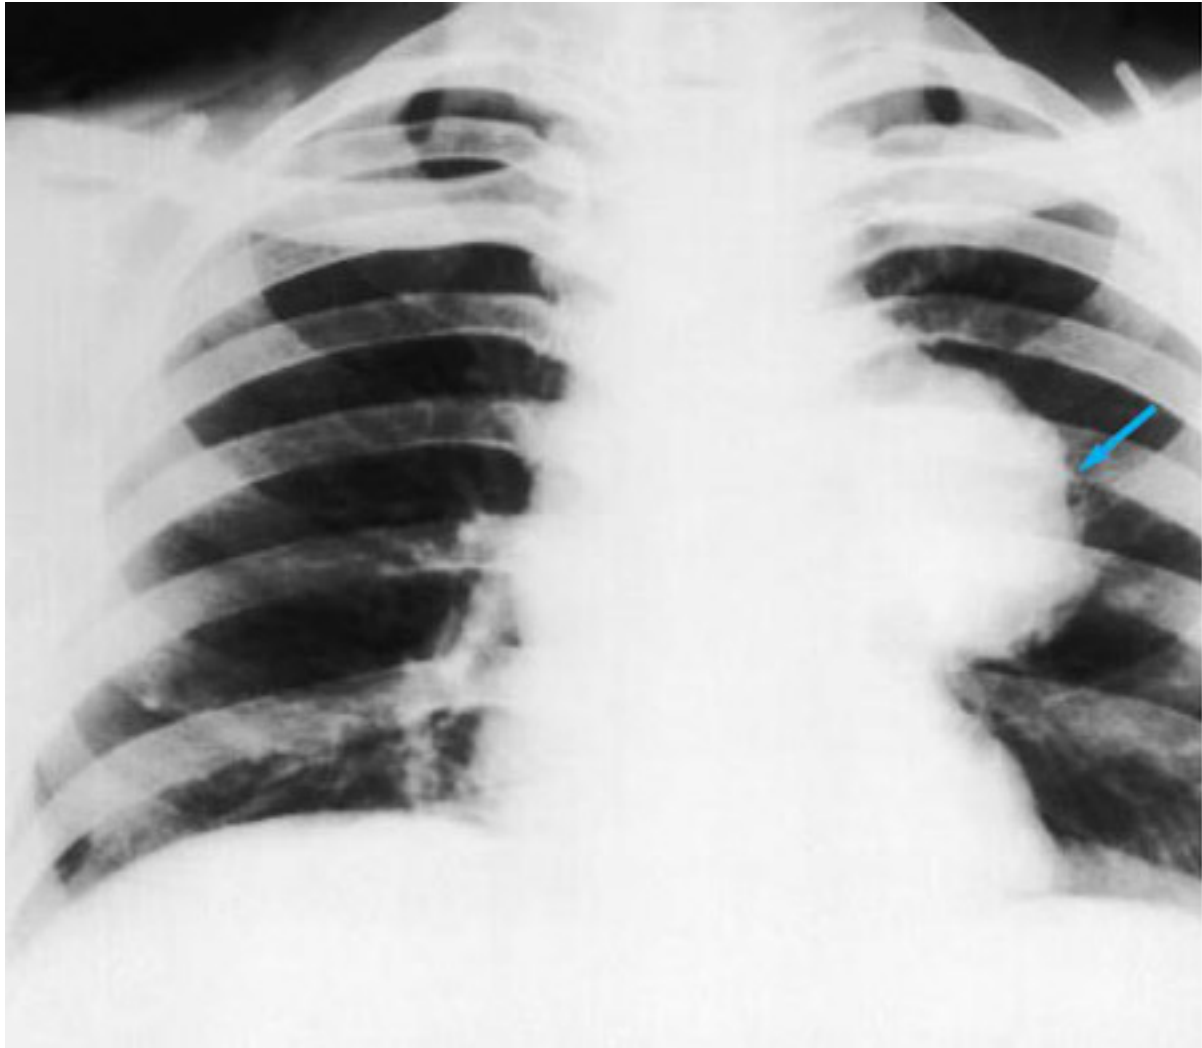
Chest x-ray showing bilateral hilar adenopathy in a patient with sarcoidosis*
